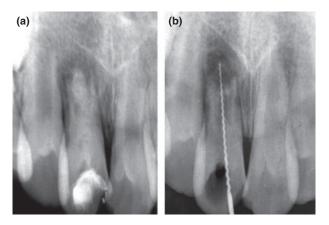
(a) Radiographic view of the lateral incisor at first visit; (b) The extent of inflammatory root resorption as viewed radiographically.
